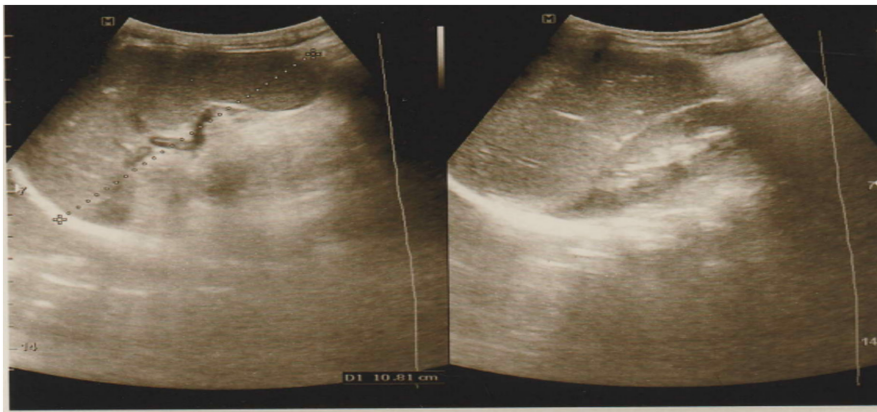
Abdominal ultrasound revealed multiple small variable sizes ill-defined hypoechoic lesions.
